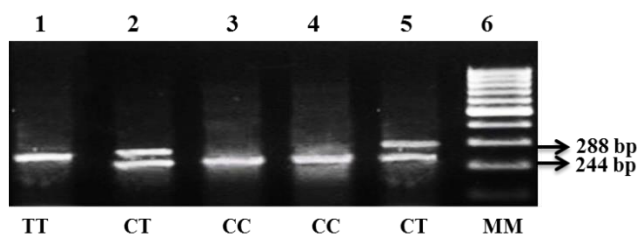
Lane 1 shows the TT genotype with a 288 bp band, Lanes 2 and 5 show the CT genotype, Lanes 3 and 4 show the CC genotype, and Lane 6 contains the molecular ladder.
